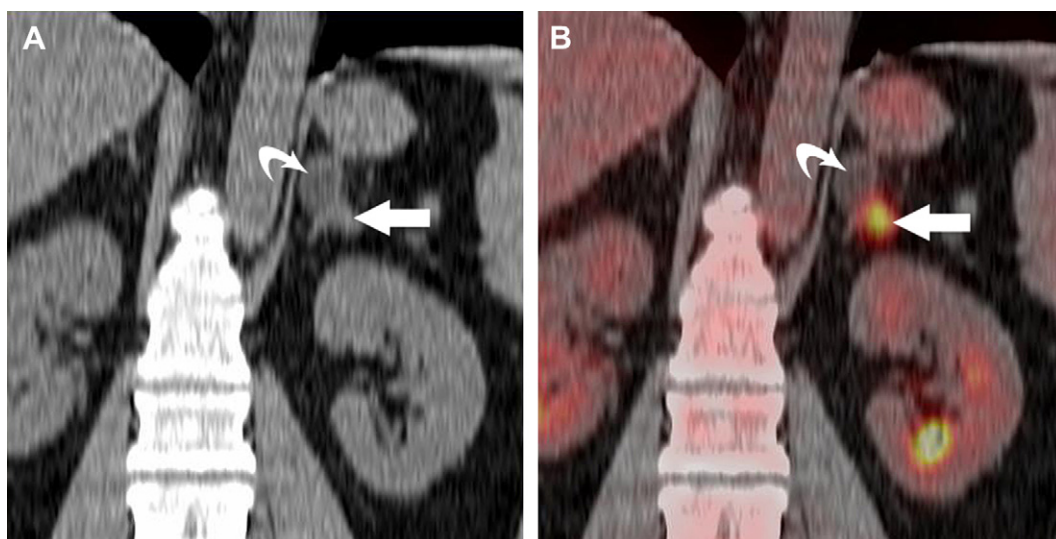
Collision tumors. Coronal reconstruction of contrast-enhanced CT scan (A) shows low-density left adrenal lesion (*curved arrow*) stable compared with previous scans consistent with an adenoma in a patient who had breast cancer. CT scan, however, also shows a new enhancing mass (*arrow*) in left adrenal. Overlaid PET/CT image (B) demonstrating that the new lesion shows increased FDG uptake, consistent with breast cancer metastasis, displacing the low-density, non-FDG-avid adenoma (collision tumors).
